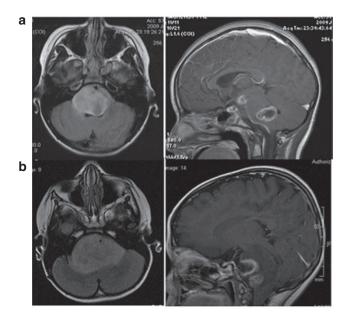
Typical magnetic resonance imaging images of diffuse intrinsic pontine glioma (DIPG). Axial fluid-attenuated inversion recovery (left) and sagittal T1 with contrast (right) of a (a) more dorsally located DIPG and (b) more ventrally located DIPG. Figure reproduced with permission from Oxford University Press.
